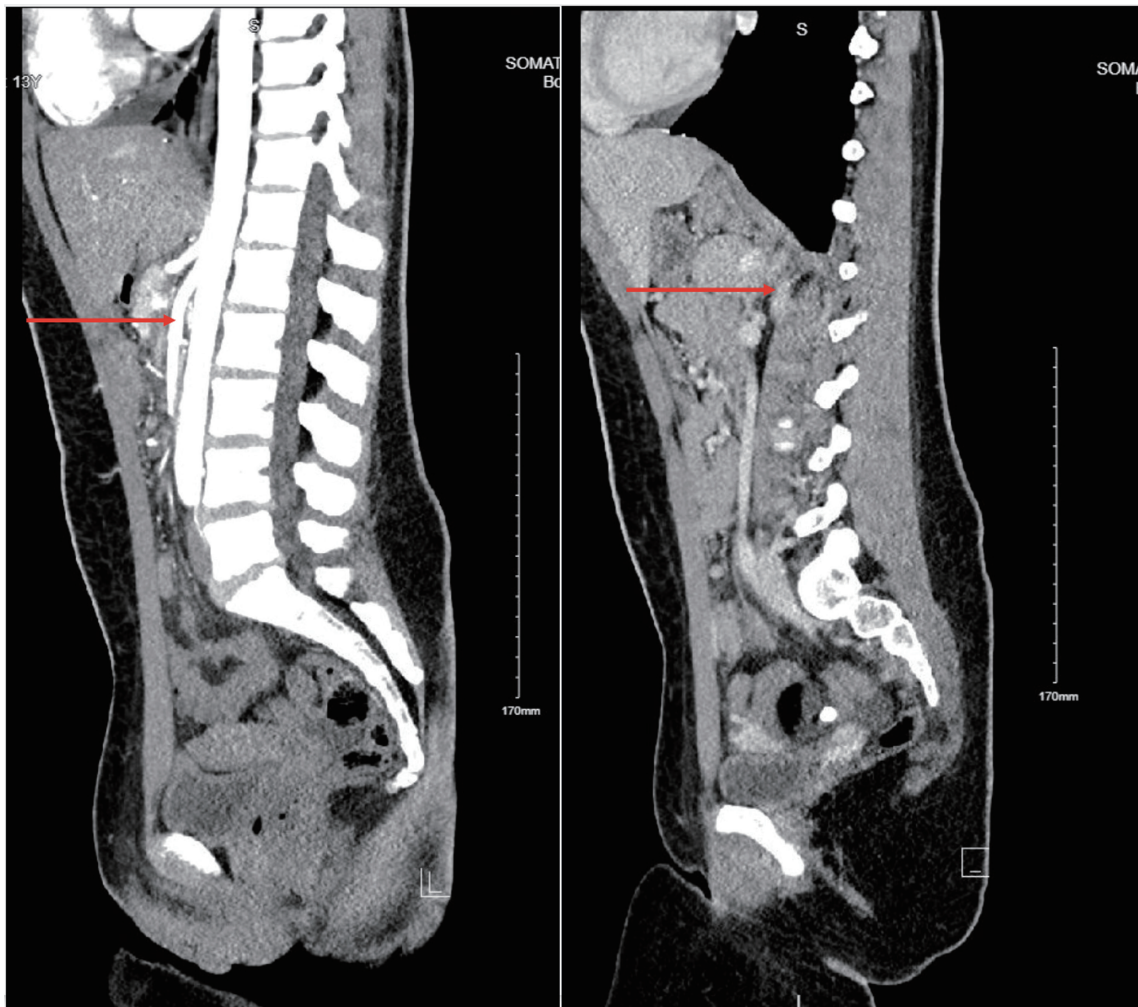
CT abdomen, sagittal views. Sagittal CT images of the abdomen demonstrating findings suggestive of SMA syndrome. The aortomesenteric angle (red arrow) and distance of the SMA, measuring 24° and 4 mm, respectively, are both below the normal range (38–65° and 10–28 mm). The celiac trunk, SMA, bilateral renal arteries, and inferior mesenteric artery are patent. The stomach and duodenum are under distended, with mild fullness of the distal second portion of the duodenum; however, no definite dilatation of the duodenum or stomach is identified. CT, computed tomography; SMA, superior mesenteric artery.
